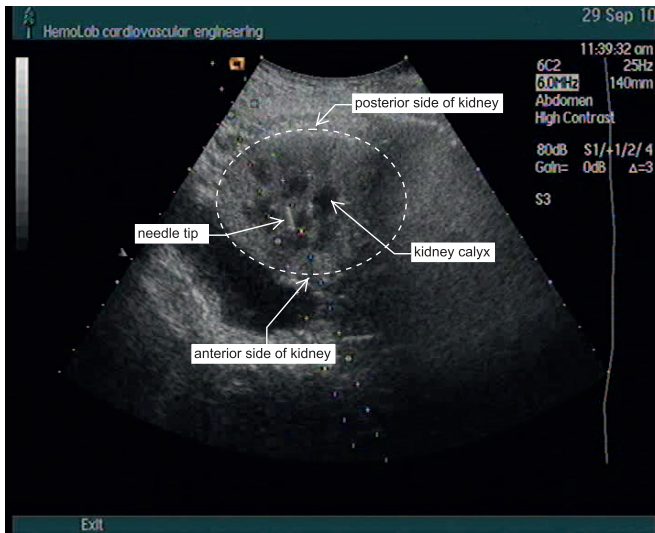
Ultrasound still from run 13 showing the approximate location of the needle tip inside the kidney
